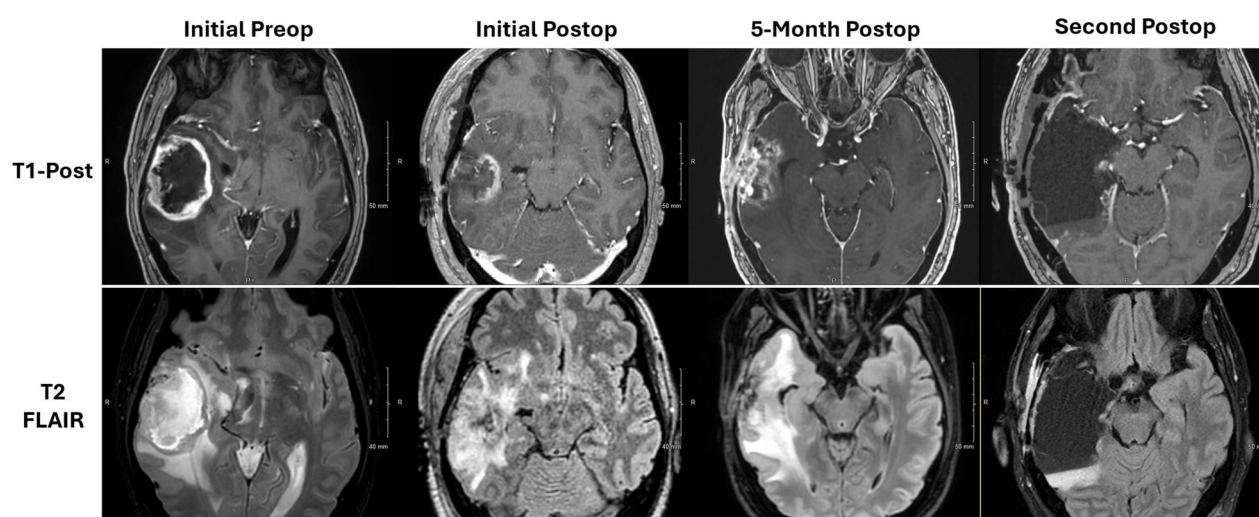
T1-post contrast and FLAIR MRIs from a 60-year-old male with a right temporal glioblastoma (IDH-wt, WHO grade 4) who underwent an initial RANO Class 3A resection at an outside hospital and experienced early perilesional recurrence, then subsequently underwent a temporal lobectomy. According to data published by Karschnia *et al* [26], extending his resection from a Class 3 (subtotal) to Class 1 (supramarginal) at his index operation would have extended his median overall survival by 9 months (15 to 24 months) when combined with standard radiation and TMZ.
